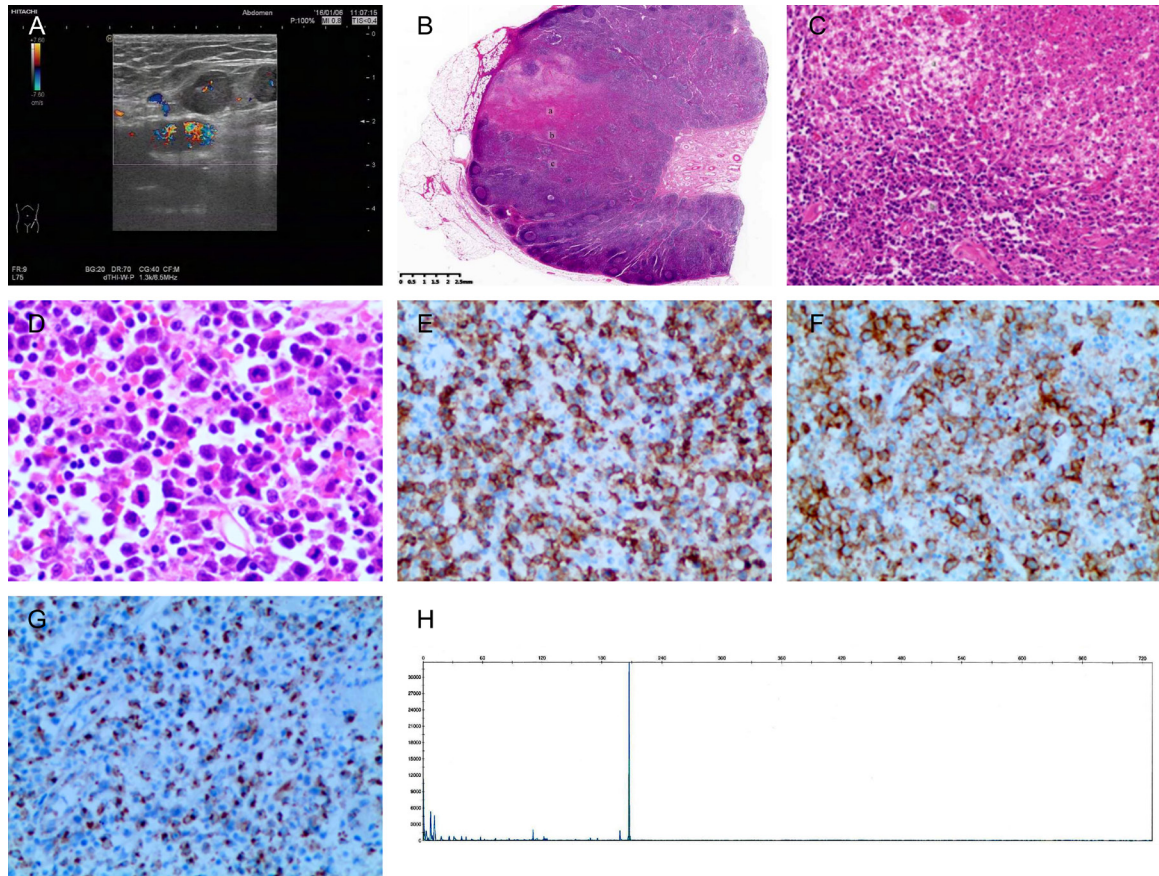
Kikuchi's lymphadenitis in inguinal lymph nodes. A. Ultrasonic image of inguinal lymph nodes. B, C. The normal architecture of the regional lymph nodes were partly damaged, a, b, and c exhibited central coagulative necrosis, borderline of mononuclear cells, and peripheral proliferative lymph tissues, respectively (HE, Original magnification $\times 6$ and $\times 50$, respectively). D. A mixture of immunoblasts, lymphocytes, histiocytes, and plasmacytoid dendritic cells, some of which may demonstrate atypia (HE, Original magnification $\times 400$). E-G. Mixture of mononuclear cells positive for CD3, CD30, and CD68 (EnVision method, Original magnification $\times 200$). H. Unspecific amplification of IGH.
